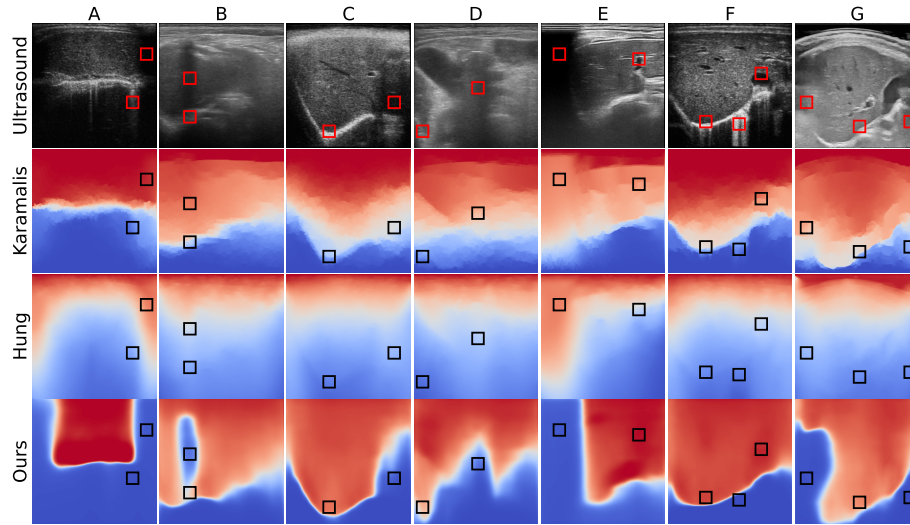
Ultrasound frames (before scan conv.), with confidence maps generated by three methods. Red ■ and blue ■ represent high and low confidence, respectively. The squares on the confidence maps show regions of interest. *See text for details.*
